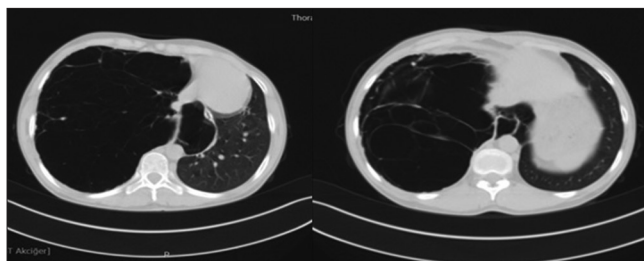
Computed tomography of the chest taken at presentation
